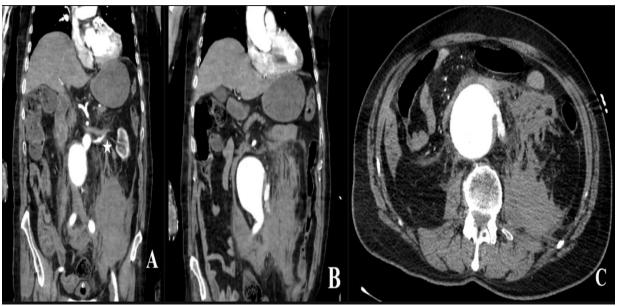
Preoperative computed tomography angiogram images. The coronal images (A, B) show aortic abdominal aneurysm below the renal artery (star in A). Ruptured aneurysm at the left lateral wall in B and C.
